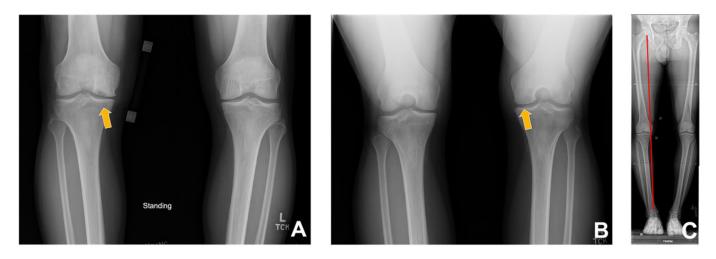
(A) Initial anteroposterior and (B) posteroanterior radiographs demonstrating lucency (arrows) in the medial femoral condyle consistent with an osteochondral defect and a preserved joint space. (C) Long-leg radiograph demonstrating a significant 10° varus deformity with malalignment through the affected compartment.
